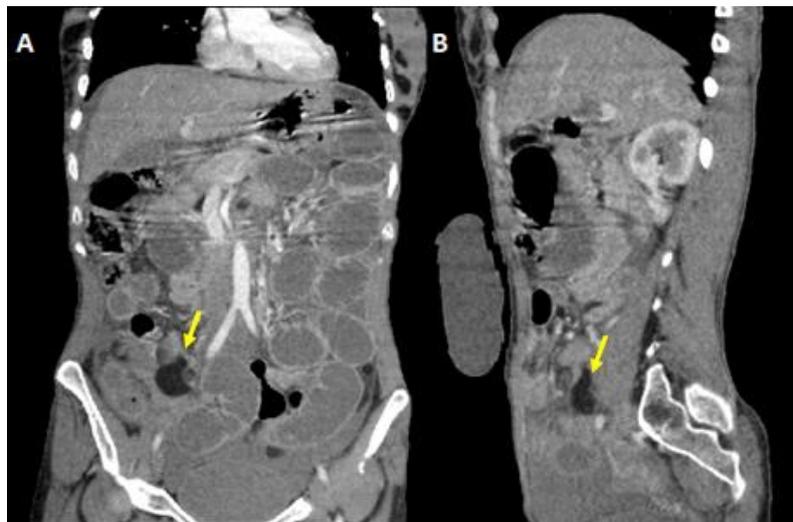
A: coronal plane, B: sagittal plane. CT scan showed the fatty formation (yellow arrow)
